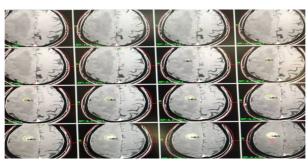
MRI with contrast sent to the gamma knife computer and targeting the MBTs done by neurosurgeon.
